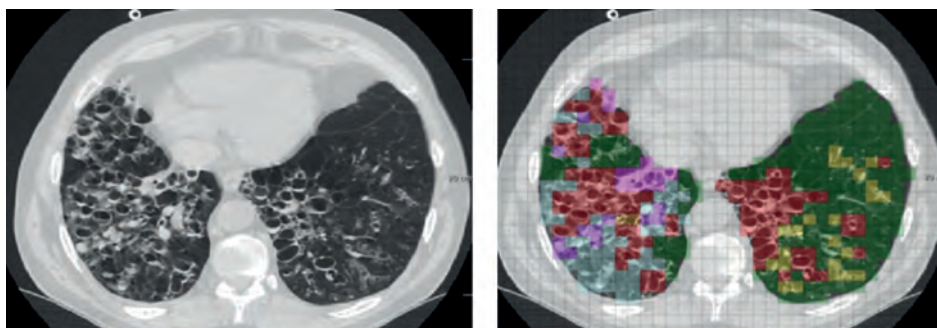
CT slice scored with the BEST-CT
